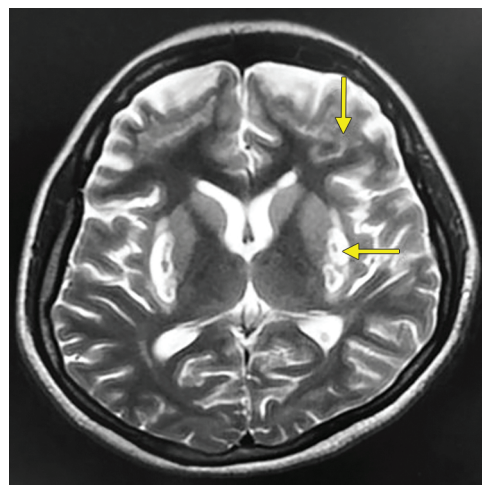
T2-weighted (T2W) MRI showing hyperintensities suggestive of toxic encephalopathy (yellow arrows)
